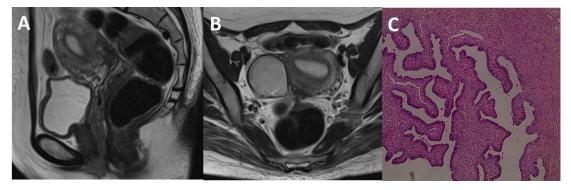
A, B. Sagittal and axial T2-weighted MR image shows a large cystic ovarian tumor of 5 cm at maximum diameter. The tumor had arisen from the right ovary, the margin was smooth and the uterus was normal size. C. Ovarian endometrioid tumor of low malignant potential showing glands similar to the complex hyperplasia of the uterine endometrium.
